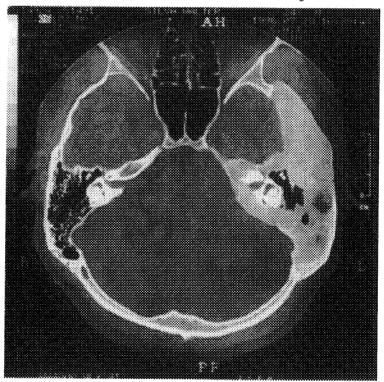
CT scan: shows the left temporal bone disorder, but not affecting the middle ear cavity and labyrinth.
